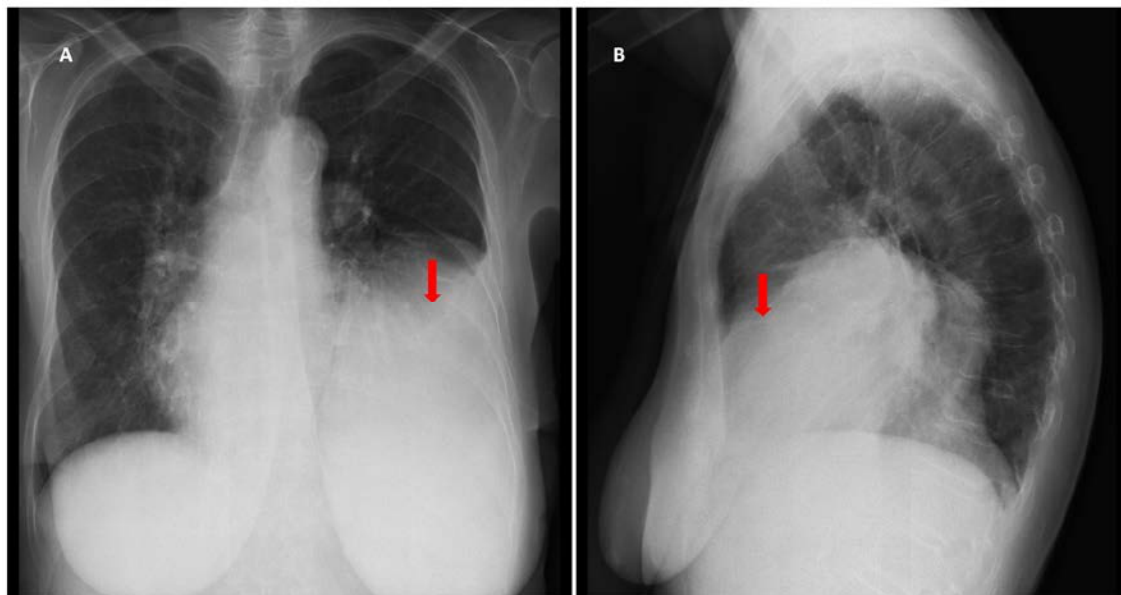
Chest x-ray. A. Frontal view. B. Left lateral view. On the left, there is a homogeneous shadow with an upper indistinct border at the level of rib IV anterior segment (arrow), due to effusion mainly in the anterior sinus.
